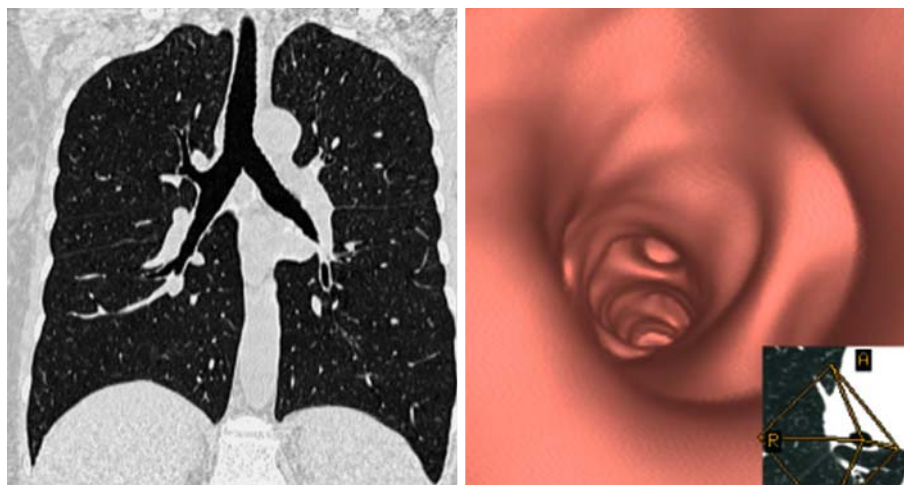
Multi-detector row CT (MDCT) in a patient with normal airways. *Left:* Multiplanar reformation (MPR) in coronal oblique direction along the long axis of the trachea. *Right:* virtual bronchoscopy showing a descending view of the basal divisions in the right lower lobe from the intermediate bronchus
